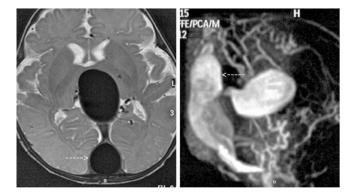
MRI (A) Axial T2WI and (B) MR venography show an aneurysmally dilated median vein which drains into a falcine sinus (arrow).
